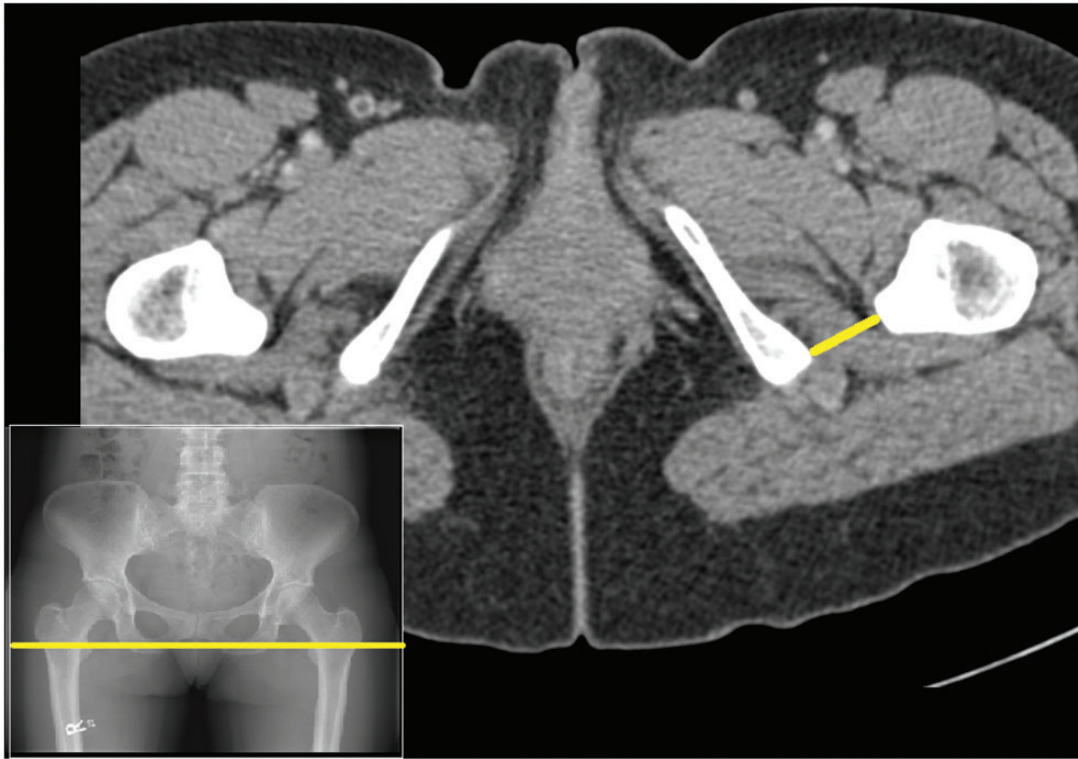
Axial CT images through the level of the lesser trochanter showing the IFD.
